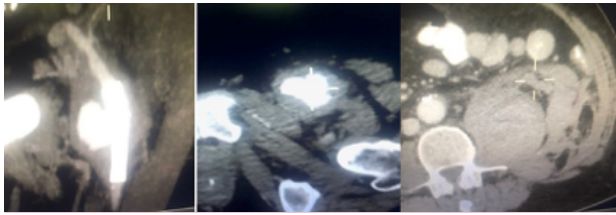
Computed tomography angiography: contained rupture of a common femoral artery pseudoaneurysm at the level of the previous stent implantation site with ipsilateral retroperitoneal hematoma
